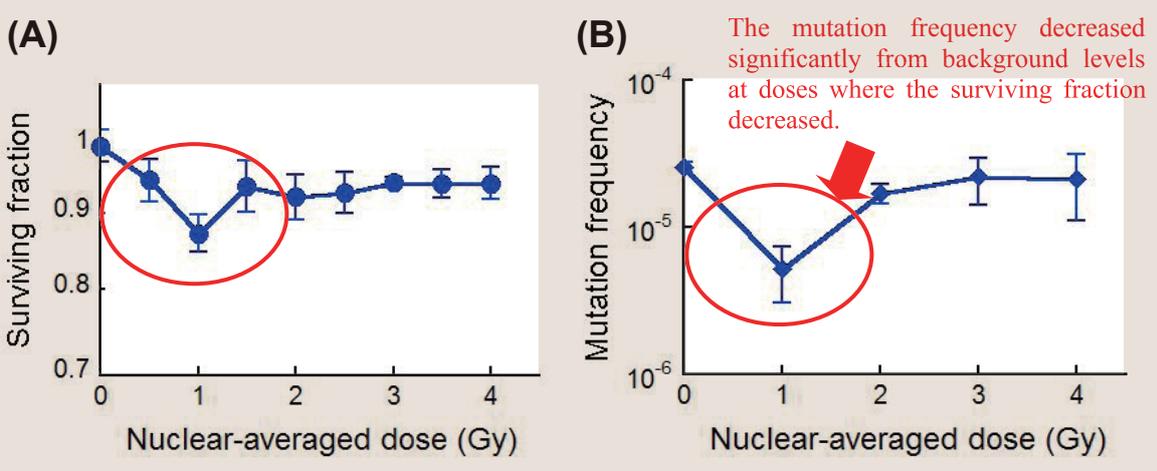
Suppression of spontaneous mutation by X-ray-induced bystander response
